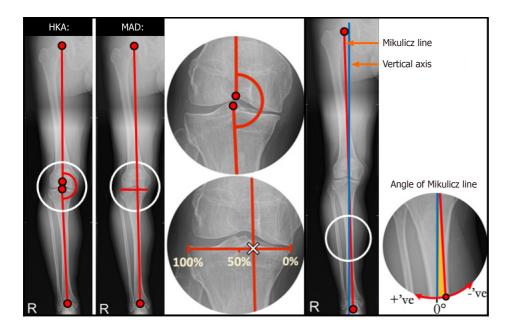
Radiographic representation of the hip knee ankle angle, mechanical axis deviation and the angle of Mikulicz line. The white cross represents the position through which the mechanical axis of the lower limb intersects the tibial plateau. HKA: Hip knee ankle angle; MAD: Mechanical axis deviation.
